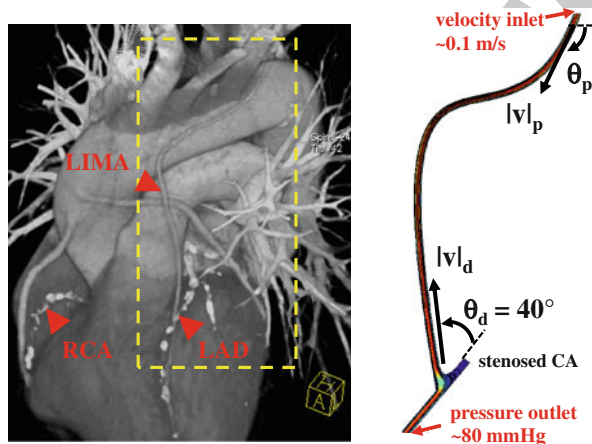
Post-operative CT scan of the complete revascularization procedure (left). Right coronary artery (RCA), left anterior descending artery (LAD), and left internal mammary artery (LIMA) are marked with arrows. The area inside the dashed lines indicates the anatomical section of 2D shape optimization. In-plane geometrical features of the LIMA graft were extracted from the CT image (right). In-plane optimization of the LIMA graft model was based on four design parameters; the proximal ( $\theta_p$ ) and distal ( $\theta_d$ ) anastomosis angles, proximal ( $v_p$ ) and distal curvature vectors ( $v_d$ ). Inlet and outlet boundary conditions are labeled on the 2D model plotted on the left.
